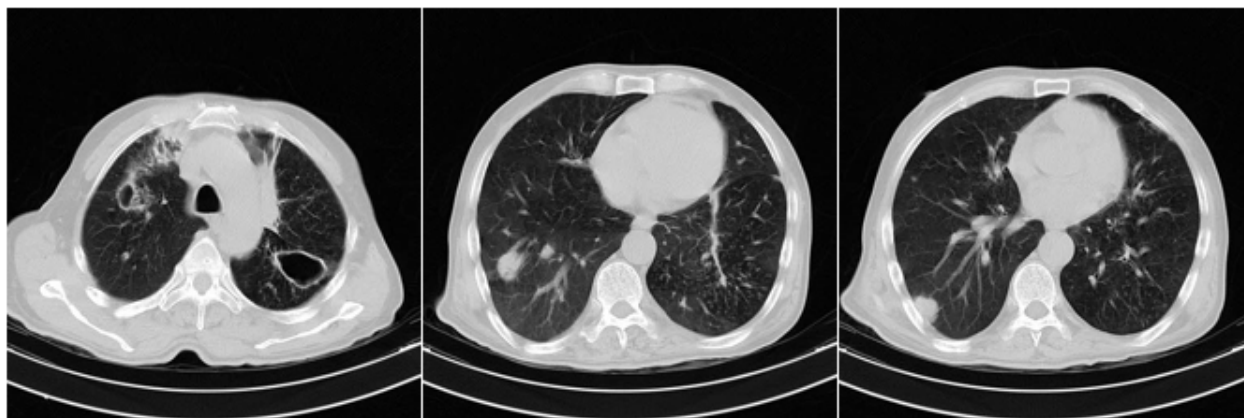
Chest computed tomography scan of our patient with positive bronchoalveolar lavage smear for tuberculosis and *Cryptococcus neoformans* show cavitations in both upper lobes along with bilateral multiple nodules
